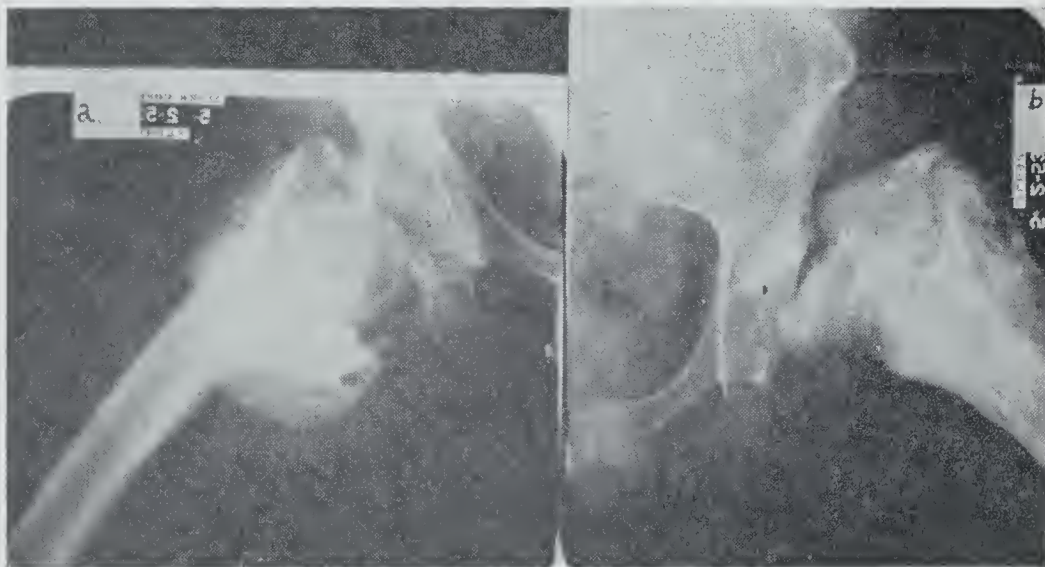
Detailed radiographs of each hip. Bilateral Charcot neuropathic joints. The right side is shown as (a) and the left as (b). There is marked sclerotic bony proliferation incident to the old fractures. Partial dislocation is present at each hip. Bony destruction and juxta-capsular fragmentation is also to be noted.
